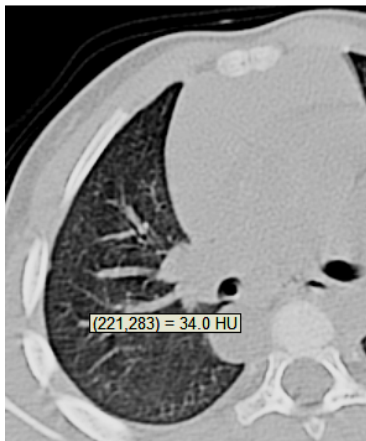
Axial CT, lung window at the level left atrium reveals fluid filled cystic lesion adjacent to right main bronchus proved to be due bronchial cyst.
